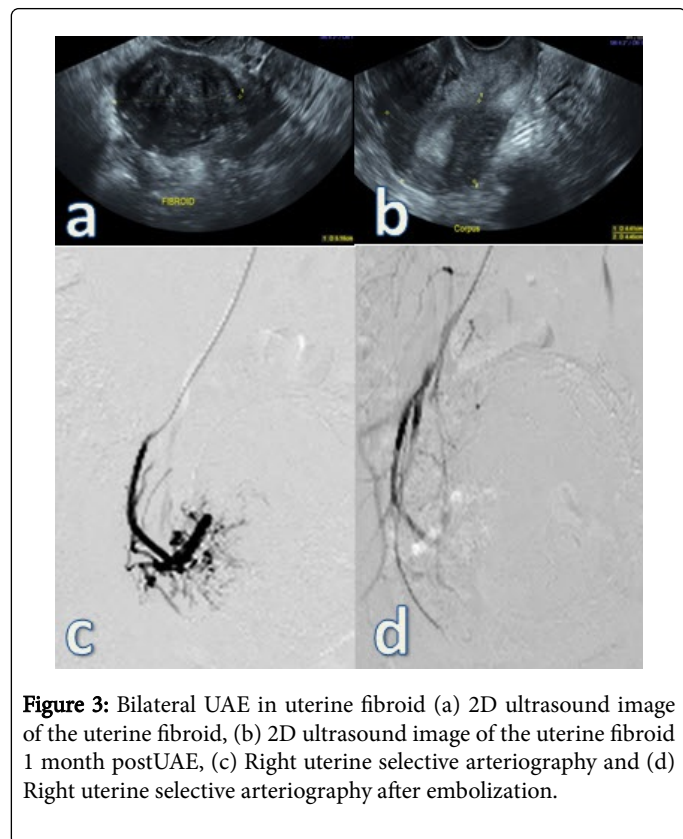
Bilateral UAE in uterine fibroid (a) 2D ultrasound image of the uterine fibroid, (b) 2D ultrasound image of the uterine fibroid 1 month postUAE, (c) Right uterine selective arteriography and (d) Right uterine selective arteriography after embolization.
